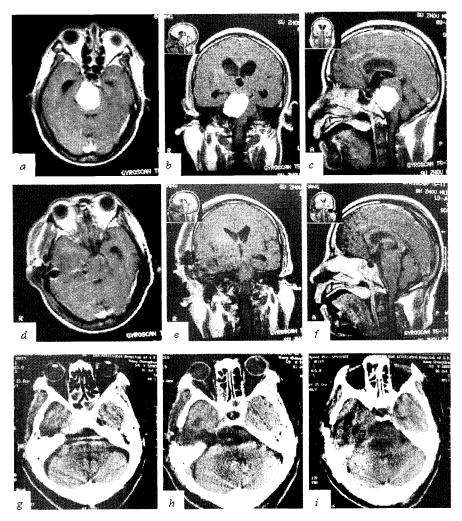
The preoperative and postoperative images of one patient with a petroclival meningioma removed via a subtemporal keyhole approach. a, b, c Preoperative MRI; d, e, f MRI on the fist postoperative day; g, h, i CT scanning performed two weeks postoperatively, revealing the bone window and the removal range of the petrous apex
